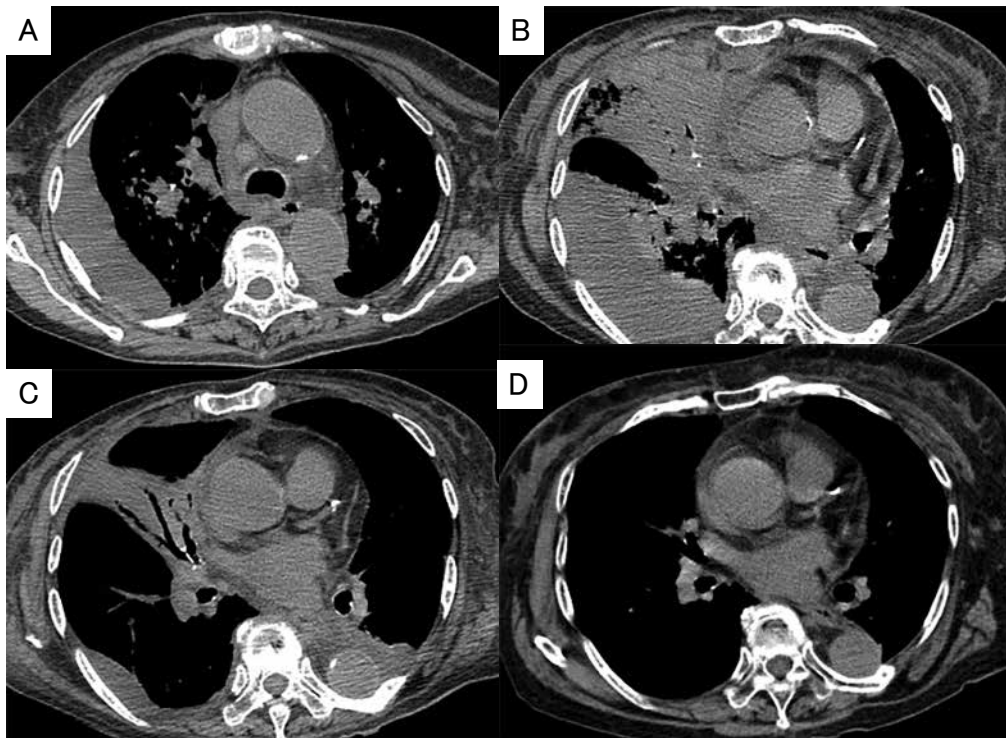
Chest CT scan on admission and after corticosteroid administration
